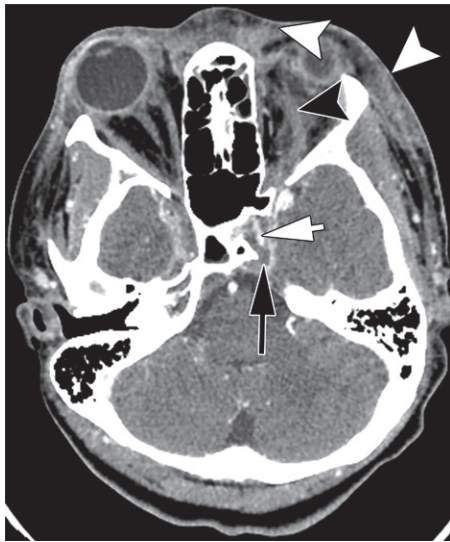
Cavernous sinus thrombosis in a 14-year-old girl. Axial contrast-enhanced CT image shows incomplete enhancement of the left cavernous sinus (black arrow), through which the enhancing internal carotid artery (white arrow) is coursing. The left superior ophthalmic vein (black arrowhead) is dilated and not enhanced. There is associated subcutaneous edema (white arrowheads) of the face and edema in the left orbit.
